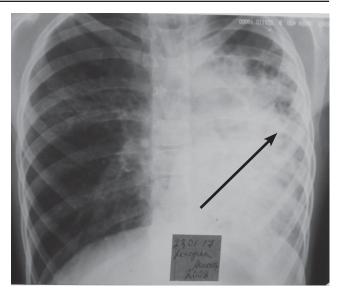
Thoracic chest radiography – left pulmonary athelectasis, total mediastinal displacement to the left, diffuse polymorphic cavity formations on the left. 8-year-old child with chronic lung infection with Ps. aeruginosa, genotype delF508/X, unfavorable evolution
